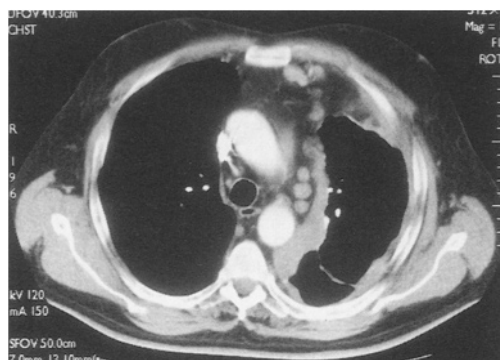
CT scan: 69 year old man with an epithelial mesothelioma. Left sided tumour with thickening of both costal and mediastinal pleura. Several enlarged nodes are seen in the mediastinum adjacent to the aortic arch
